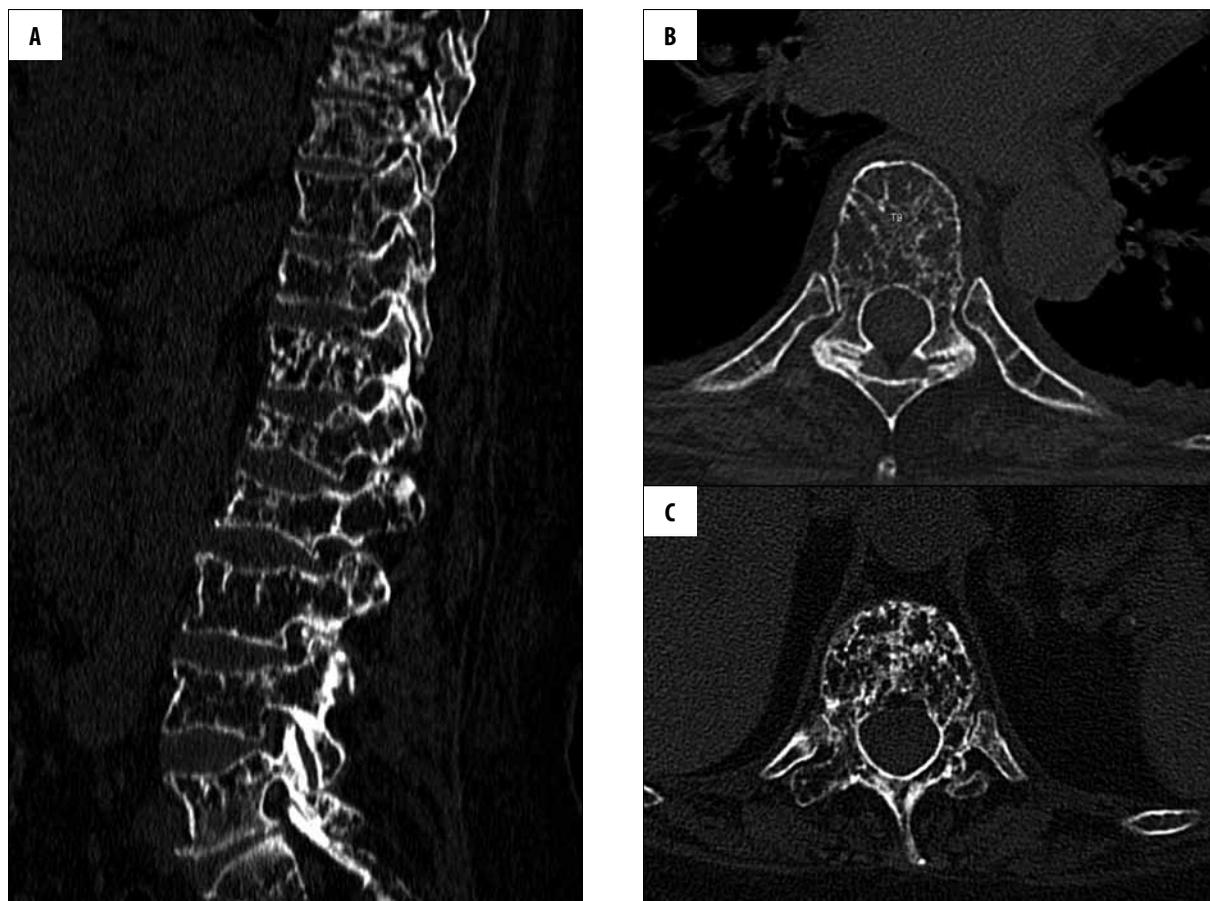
CT scan. (A) MPR reconstruction. (B) Axial plane at the level of T9 vertebra. (C) Axial plane at the level of L1 vertebra. Multiple lytic lesions throughout the spinal column, typical for disseminated myeloma with pathological fractures.
